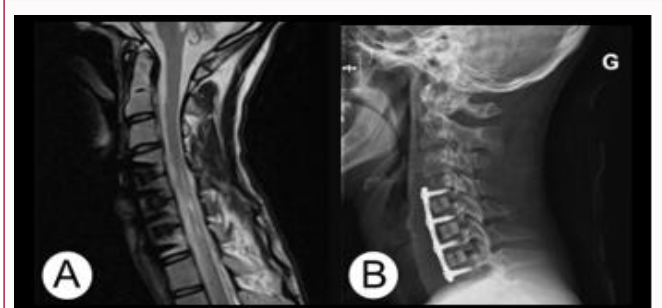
(A) Postoperative MRI neutral position. (B) Postoperative radiograph neutral position.
